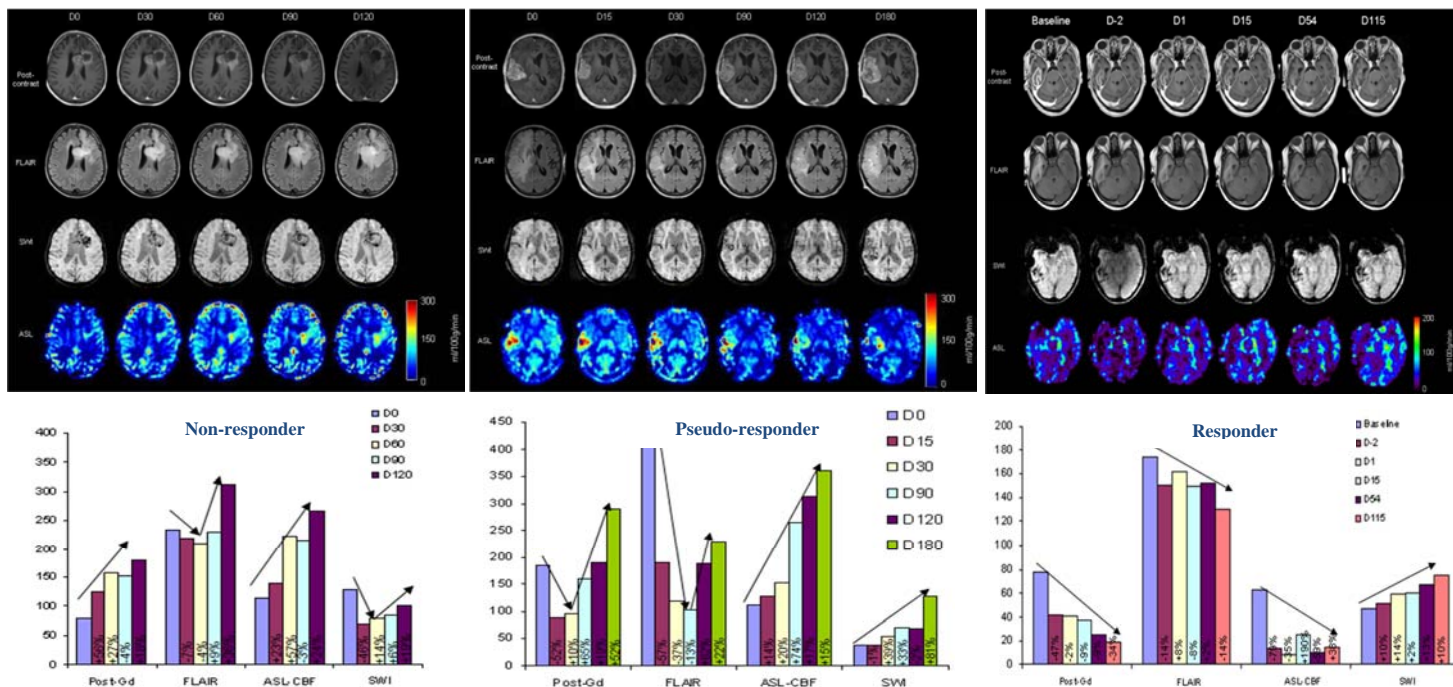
Tumor changes on post-contrast T₁ MRI, FLAIR, SWI and ASL and the corresponding tumor aggressiveness indexes measured during the longitudinal follow-up of three representative patients: Non responder, Pseudo-responder and Responder. Values in % represent variation of aggressiveness between 2 consecutive exams.
